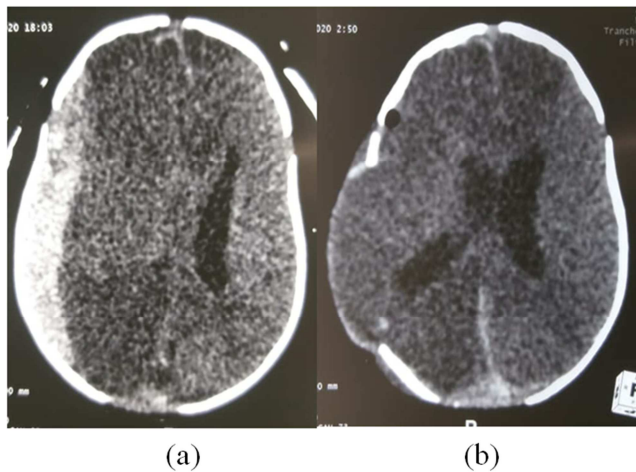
Preoperative cerebral CT (a), child aged 1 month 10 days, showing an acute right hemispherical HSD. Post-operative cerebral CT (b) showing the bony flap with expansion of the cerebral parenchyma.
